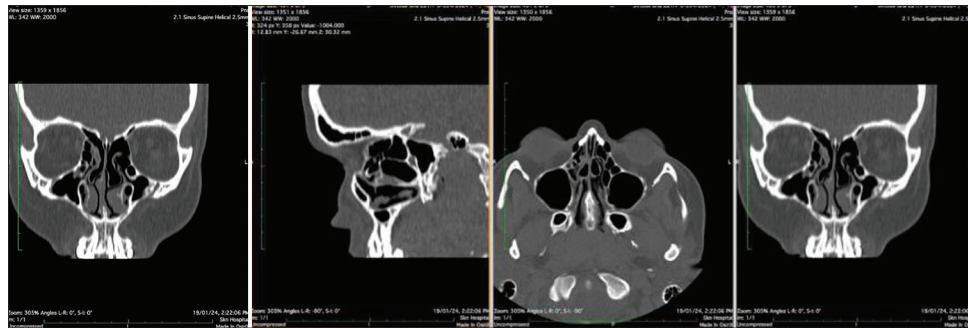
Haller cell (left infraorbital) is best visualized in the coronal plane on CT
